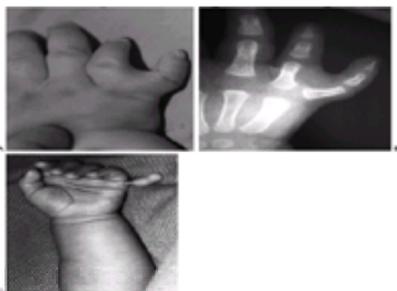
A: Complete postaxial polydactyly with phalangeal duplication with a conjoined metacarpal. B: Radiograph of the same patient. Reconstruction will consist of excision of the duplicate phalanges, contouring of the bifid metacarpal head, and transfer of the metacarpophalangeal joint ulnar collateral ligament and the hypothenar musculature to the reconstructed fifth digit. C: Simple polydactyly with only soft tissue attachment. This can be excised in the newborn nursery under local anesthesia. Be careful of suture ligature because the entire stalk needs to be excised to avoid leaving a residual nubbin.
